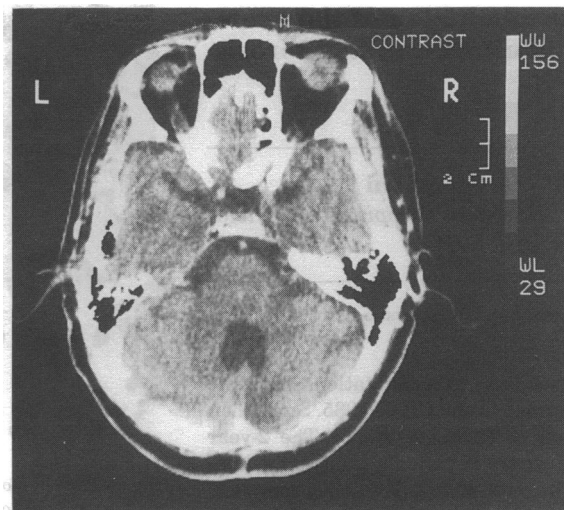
Postoperative CT-scan examination
